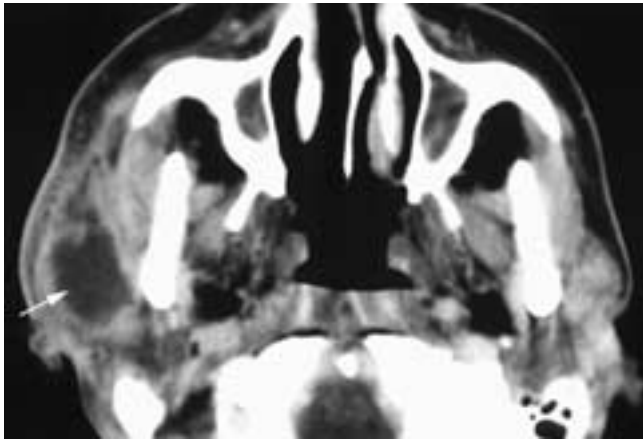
Axial contrast-enhanced CT scan shows a solitary low-attenuation area (arrow) in the right parotid gland. There is a thick, indistinct, enhancing rim, and the remaining gland is denser than normal. There is also thickening of the overlying skin and increased density in the subcutaneous fat. This patient had a parotid abscess with cellulitis.
